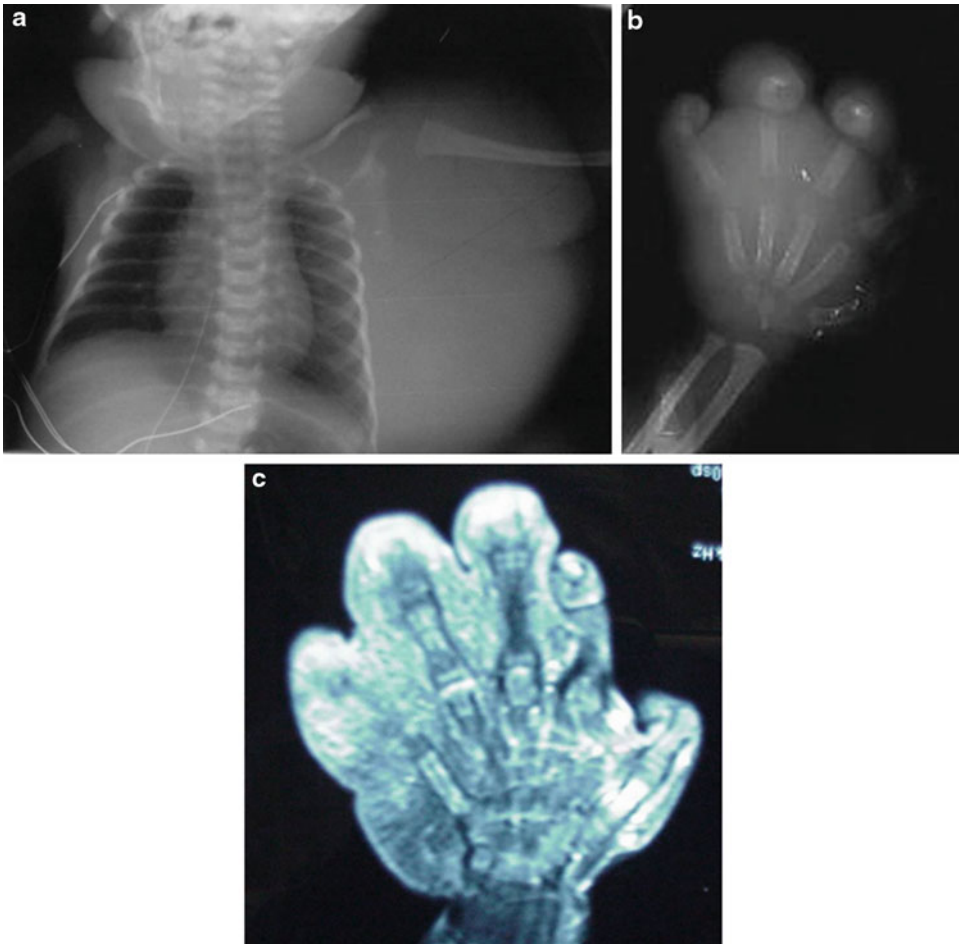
(a–c) Radiography of the chest showed a huge lobulated soft tissue mass over the shoulder, proximal humerus, and left chest wall (a). Radiography (b) and MR image (c) of the left hand showed diffuse enlarged soft tissue with infiltrative process in the subcutaneous region. No focal abnormality was seen in the visualized bones
